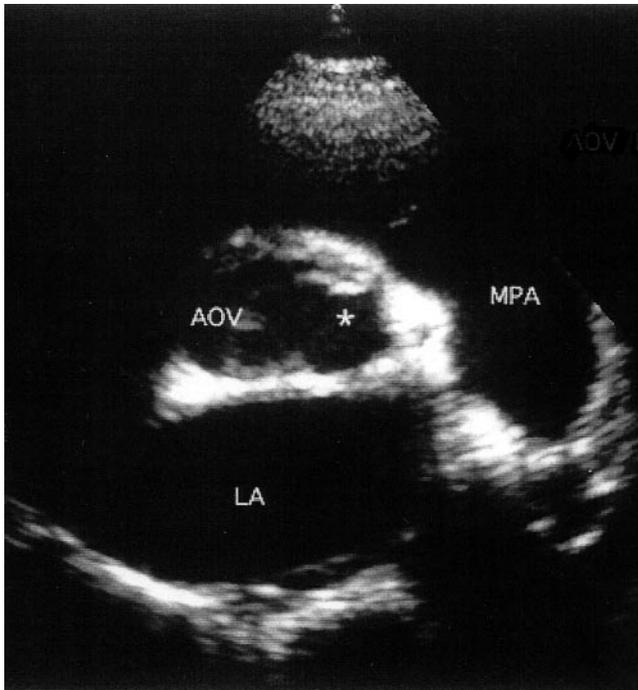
Modified echocardiographic parasternal short axis view showing prolapse of the left coronary of the aortic valve (*).
